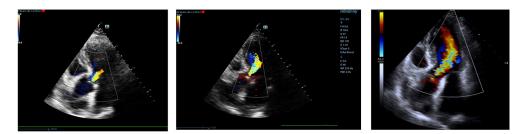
b.15. Different severities of aortic regurgitation (5-chambers view, color Doppler)
